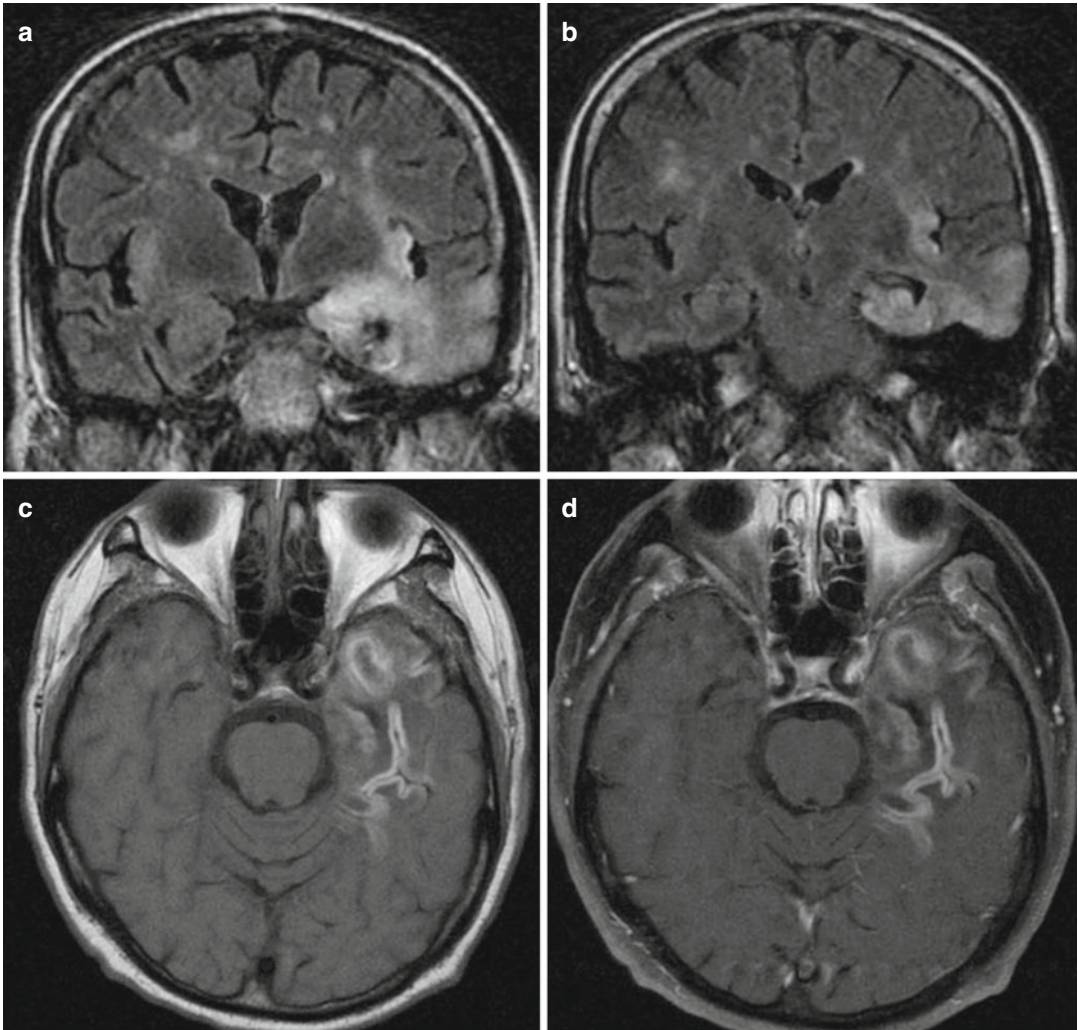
Herpes simplex encephalitis, subacute stage. Coronal FLAIR images (a, b) show dishomogeneous hyperintensity in the left temporal medial region and in the left insula. Note the mild enlargement of the temporal horn. In (c, d), T1-weighted images without
